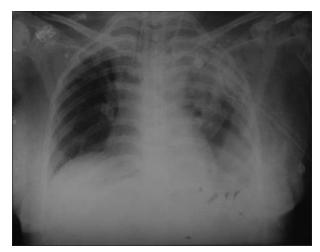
X-ray chest posteroanterior view with infiltration of left lung
